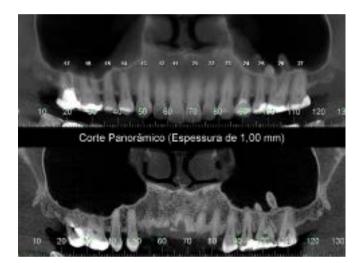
Panoramic radiography obtained from the CBCT scan.
